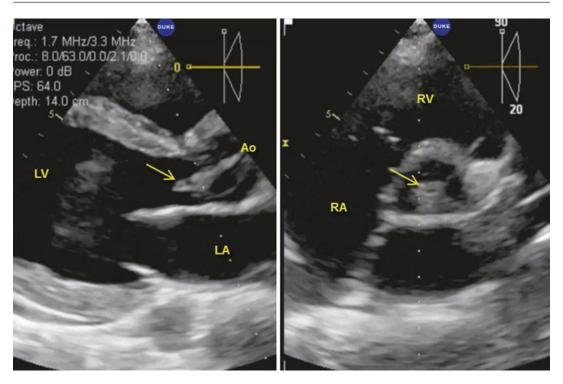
Biplane two-dimensional echocardiograms from a patient with IE in the parasternal long axis (left panel) and aortic short axis (right panel). An aortic mass is seen in both views. Image quality in this patient is quite good
